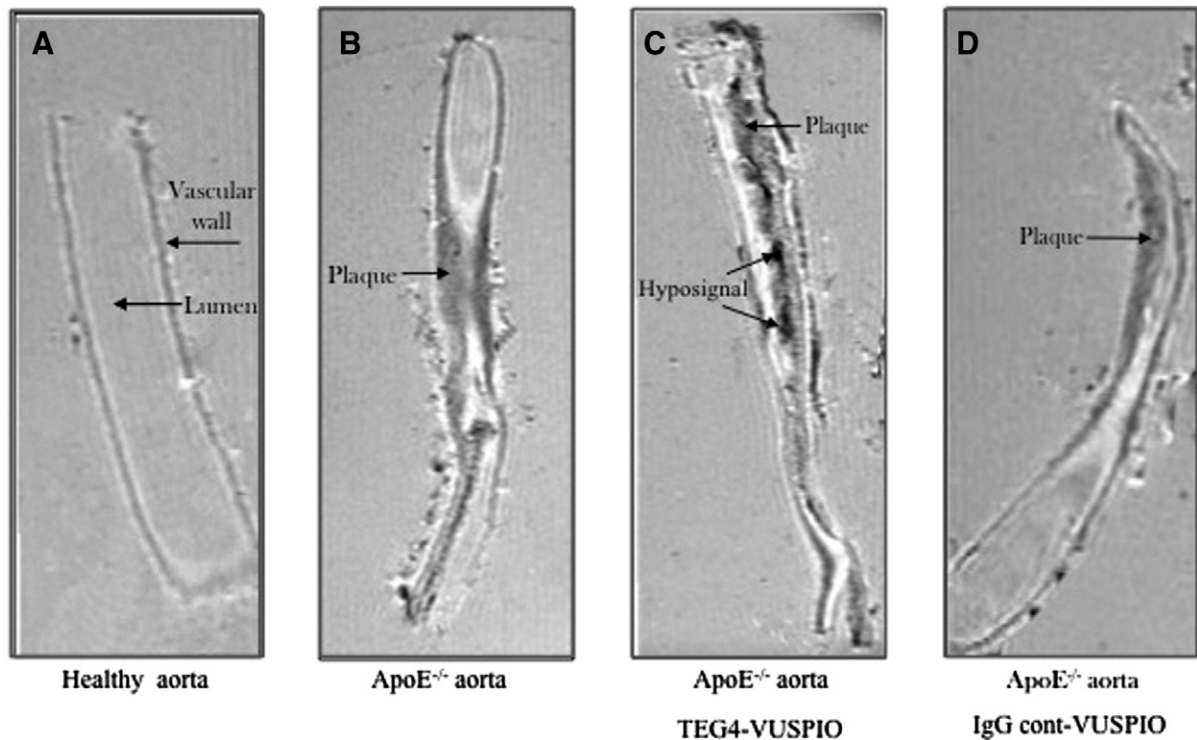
Ex vivo* MRI at 9.4 Tesla. The healthy (A) or atherosclerotic ApoE^{-/-} aorta (B, C, D) were perfused *ex vivo* with PBS (A, B), TEG4-VUSPIO (C), IgG-cont VUSPIO (D). No atherosclerotic plaque was visible in healthy aorta (A). Panel C shows an intense hyposignal due to iron deposition within atherosclerotic plaque. In contrast, no loss of signal was observed when IgG cont-VUSPIO was administered (D).
